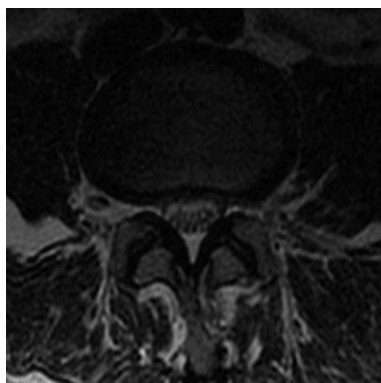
Axial T2-weighted (5000, 102) images of the lumbar spine in a 48-year-old female with congenital lumbar spinal stenosis exhibits a shallow annular disc bulge.
